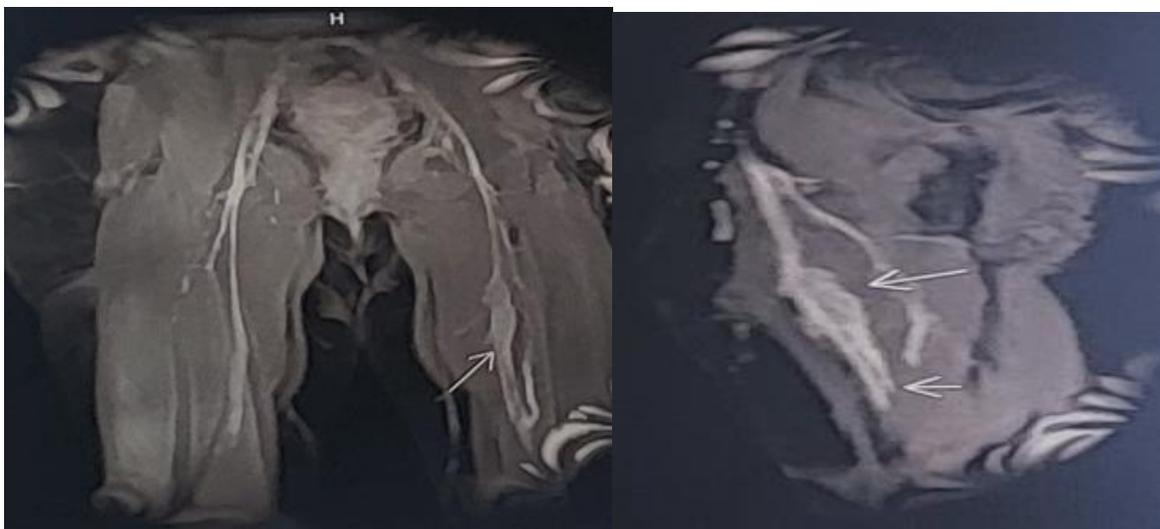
MRI showing postoperative remodelling with tumour residue
